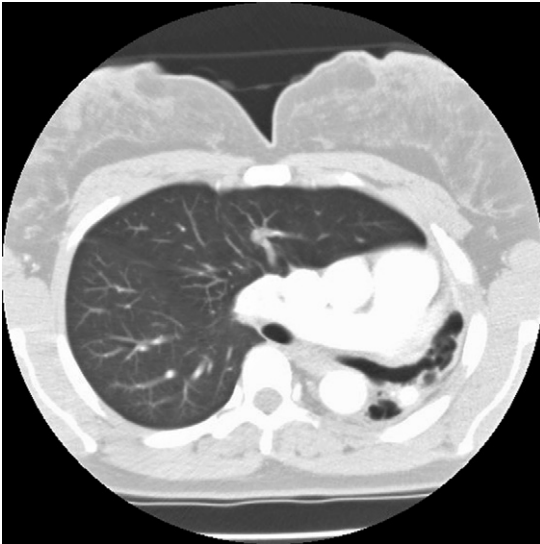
CT thorax showing left main bronchus dividing into two and ending without further divisions.
